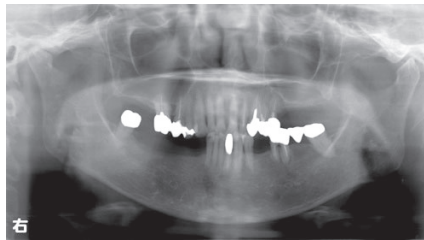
Panoramic radiograph at the first examination
